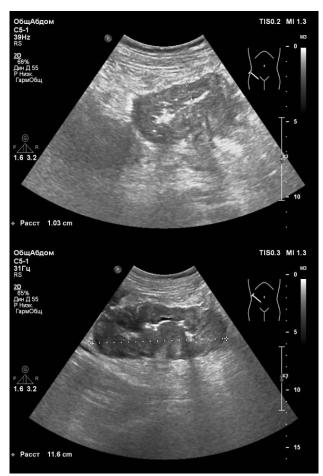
The colon wall thickening at abdominal ultrasonography
